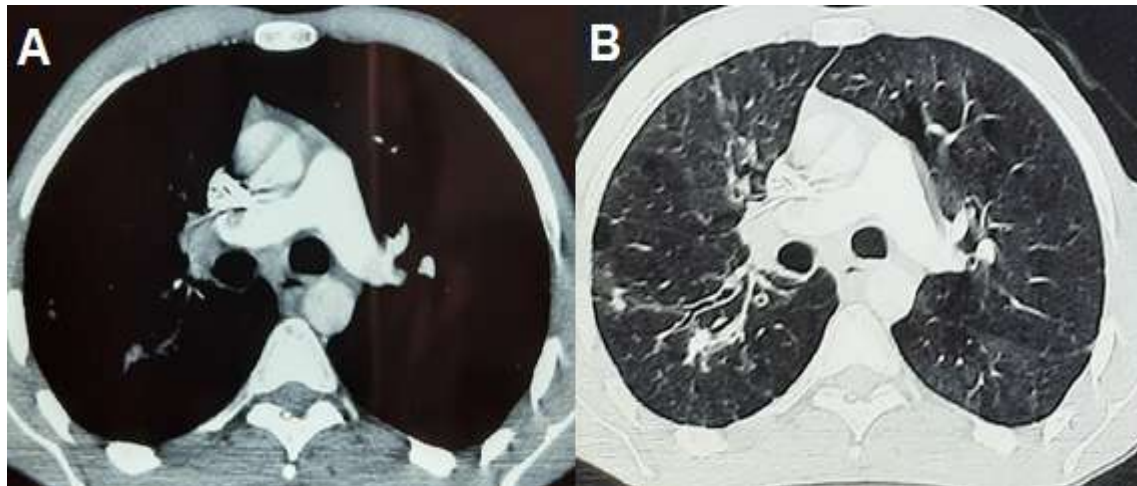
(A) Mediastinal window and (B) parenchymal window images of CT scan after six showing that the thrombus was still present in the right upper pulmonary artery with regression of the excavated lesion and nodular images.
